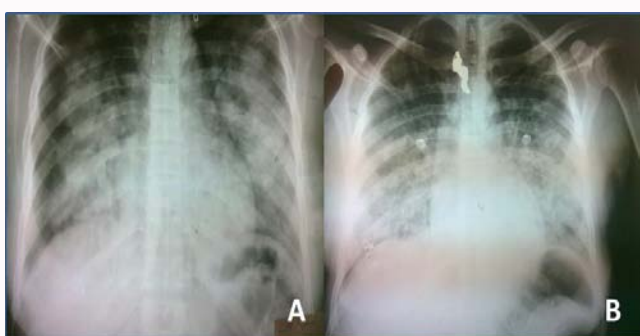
Two plain chest X-ray showing bilateral alveolar shadows on admission (A) and on discharge (B). It revealed the reported bilateral alveolar shadows persisted till the date of discharge.
